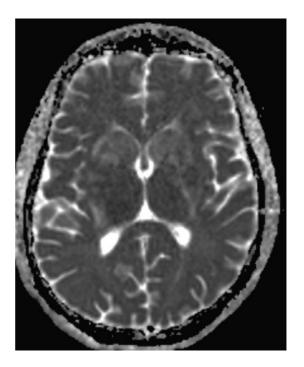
Axial Brain MRI with no restricted diffusion on ADC.
